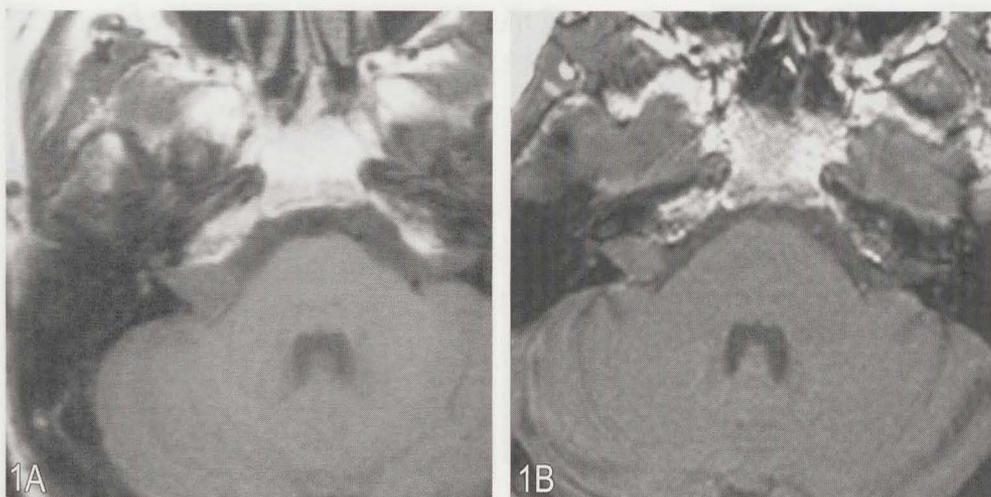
Patient 1. MRI-scans in the axial plane; the images show the largest surface of the tumor, initially (A) and after 9 years follow-up (B). See also Table 3.
